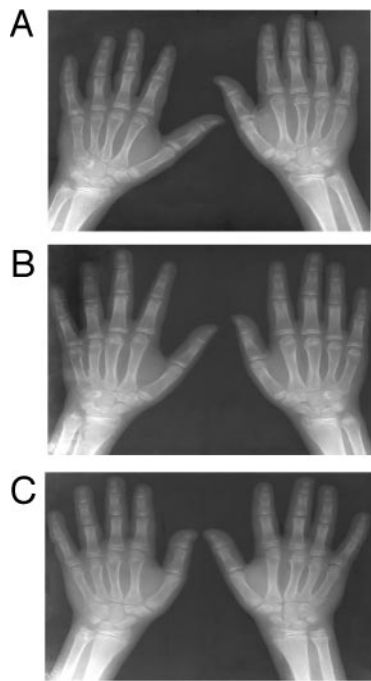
Baseline hand and wrist radiographs of sibling 1 (A; BA 12.5 yr), sibling 2 (B; BA 13 yr), and sibling 3 (C; BA 11.5 yr) before GH therapy.
